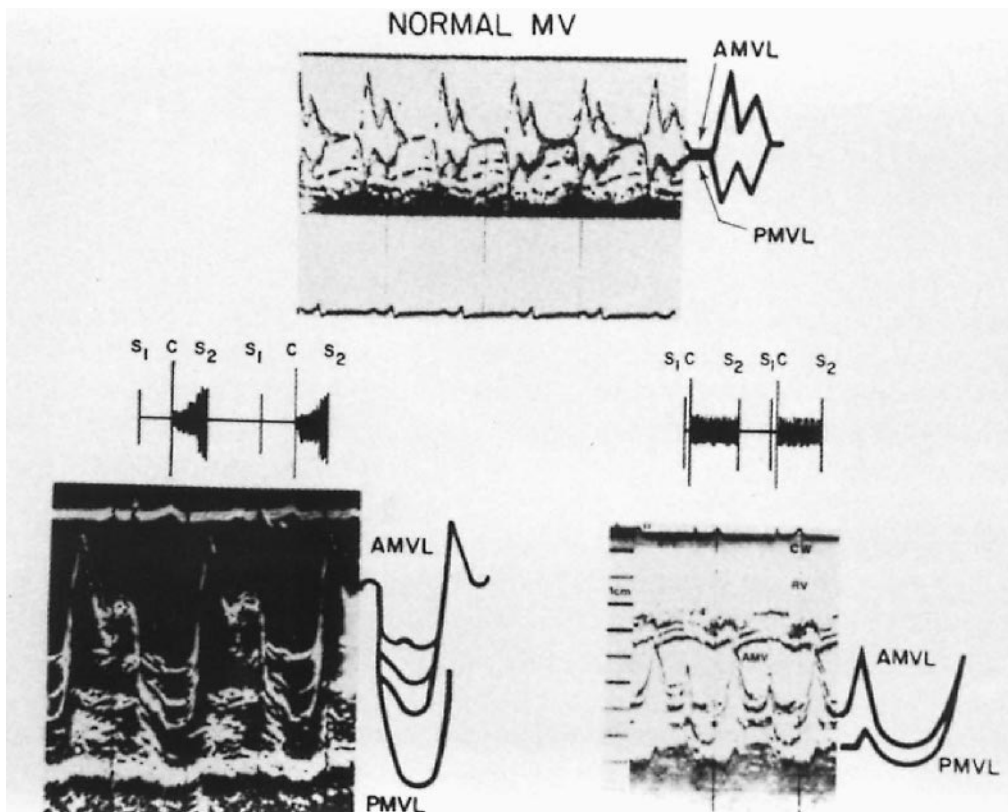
Normal M-mode echocardiogram; echocardiograms showing two types of mitral valve prolapse and simultaneous echocardiograms and phonocardiograms. AMVL = anterior mitral valve leaflet; PMVL = posterior mitral valve leaflet; MV = mitral valve. (Reprinted with permission from Ref. 117.)
